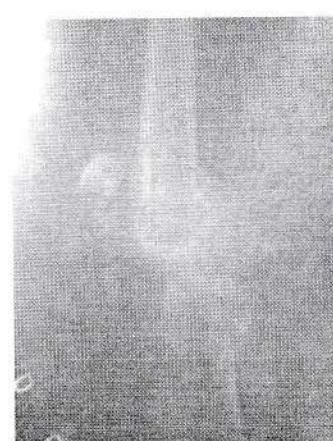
Pre operative X-ray fracture patella
